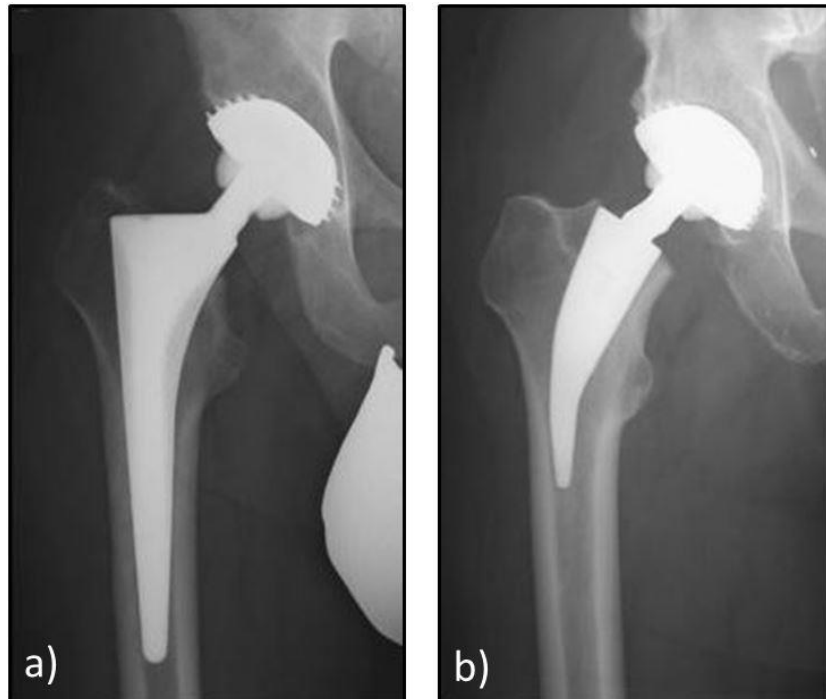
X-ray images of primary THA (Schmidutz 2012a):
